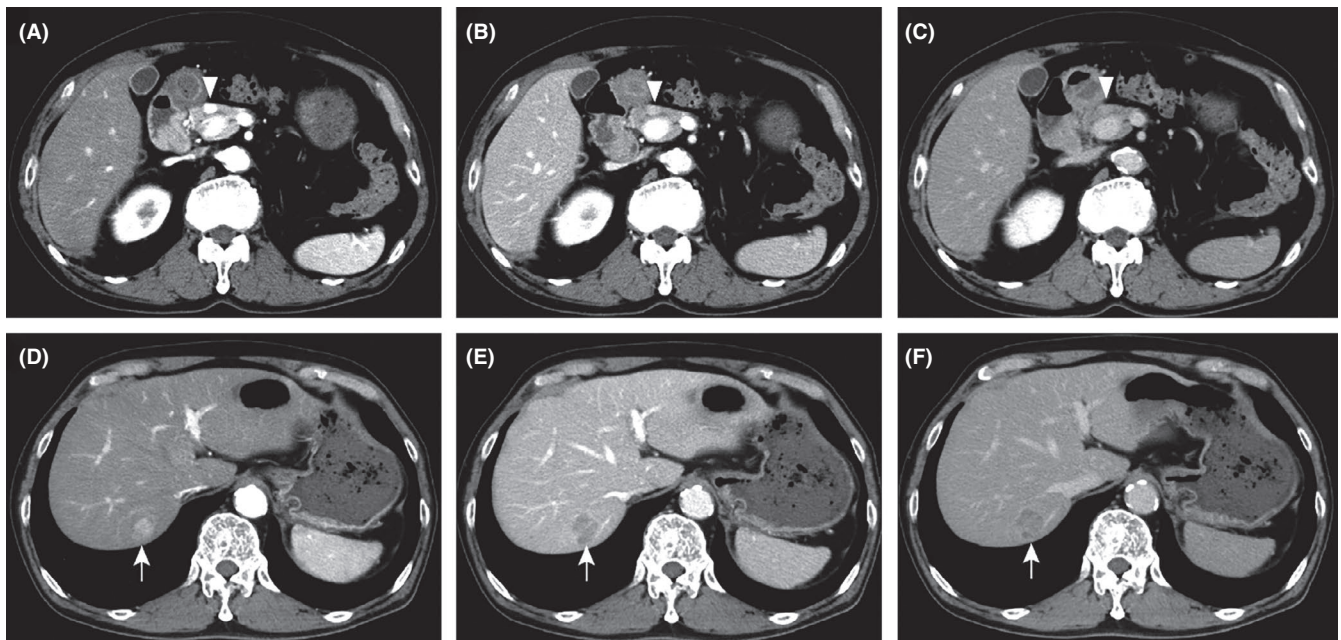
Computed tomography (CT) images. The pancreatic tumor (arrowhead) was located in the head of the pancreas and showed strong early enhancement in the arterial phase (A). The contrast medium was gradually diminished in the portal phase (B) and delayed phase (C). The liver tumor (arrow) was located in segment 7, with early enhancement in the arterial phase (D). The contrast medium was washed out in the portal phase (E) and delayed phase (F).
